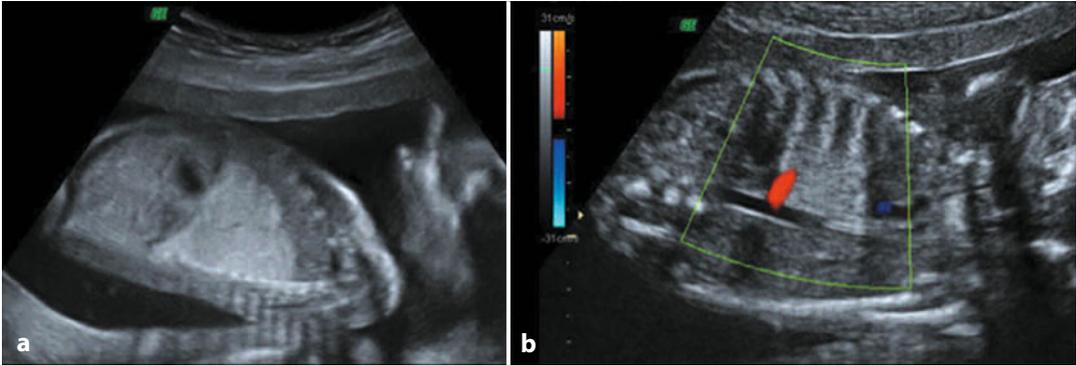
Fetal ultrasound in which a condensation is visible in the lung (a). Upon color-Doppler ultrasonography, arterial inflow from the aorta is obvious (b)
